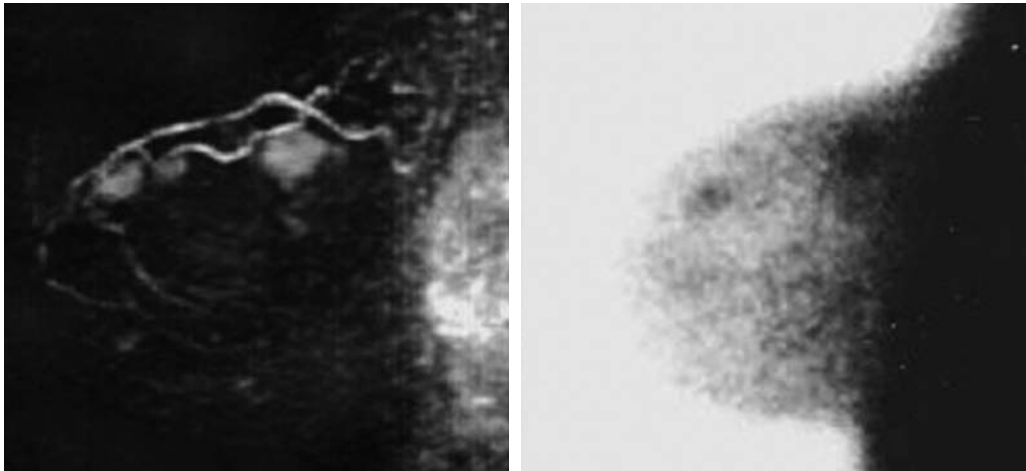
Craniocaudal view MM (a) of the right breast showing increased density and widespread microcalcifications, but no abnormality at the site of a palpable lesion. Planar prone lateral SM (b) shows a single area of focal uptake at the site of a 22-mm ductal carcinoma, confirmed by biopsy. The patient also underwent SPECT imaging (c), and focal uptake was seen in the left axilla; this was reported, but not biopsied. The patient had a right mastectomy and right axillary clearance. Follow-up MRI performed 6 months later (d) shows an abnormal left axillary lymph node (marked X). This was removed and found also to contain ductal breast cancer. From Schillaci and Buscombe 2004
